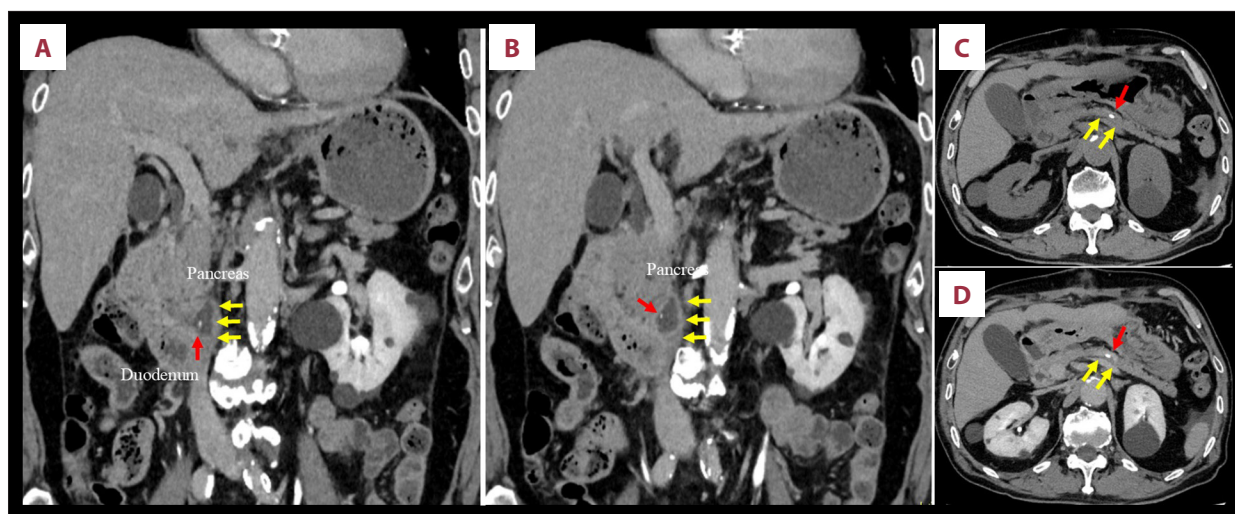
The remnant fragment within the diverticular cavity. Coronal enhanced CT images (A, B), a transverse plain CT image (C), and a transverse enhanced CT image (D) are shown. Although the first scad bone fragment, in the third portion of the duodenum, was successfully removed endoscopically, the second fragment (red arrows) within the diverticular cavity (yellow arrows) remained in place. CT, computed tomography.
